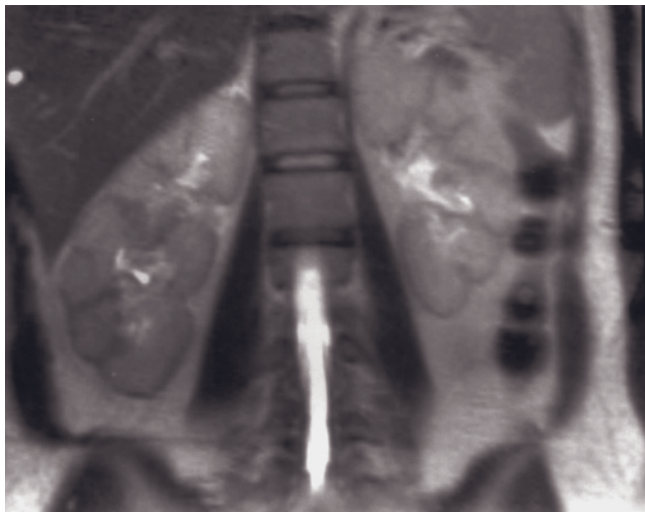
(Continued) spin-echo (c), coronal T1-weighted SGE (d), transverse T1-weighted postgadolinium venous-phase SGE (e), and coronal T1-weighted interstitial-phase 3D-GE (f) images demonstrate fused pelvic kidneys in another patient. Each kidney has its collecting system (arrows, d-f).
